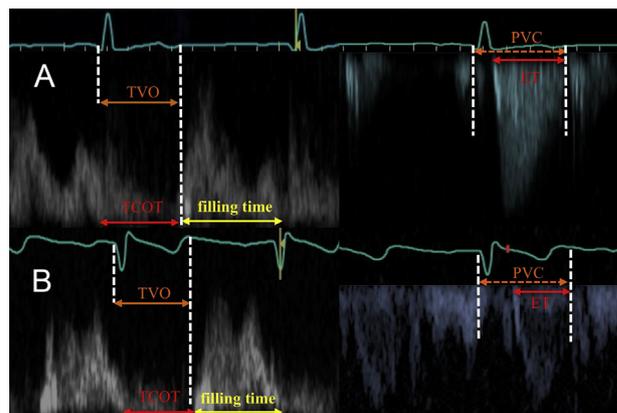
(A) Pulsed-wave Doppler RV inflow and outflow in a control subject (43 years of age) with the following values: HR = 67 bpm, ET = 331 milliseconds, TCOT = 358 milliseconds, TVO = 439 milliseconds, PVC = 427 milliseconds, and filling time = 535 milliseconds. IVRT, MPI, and percentage filling time measure 12 milliseconds, 0.08, and 60%, respectively. (B) Pulsed-wave Doppler RV inflow and outflow in a patient with EA (38 years of age): HR = 82 bpm, ET = 258 milliseconds, TCOT = 357 milliseconds, TVO = 441 milliseconds, PVC = 365 milliseconds, and filling time = 376 milliseconds. IVRT, MPI, and percentage filling time measures 76 milliseconds, 0.38, and 51%, respectively. EA, Ebstein anomaly; ET, ejection time; HR, heart rate; IVRT, isovolumic relaxation time; MPI, myocardial performance index; PVC, pulmonary valve closure time; RV, right ventricle; TCOT, tricuspid closure-to-opening time; TVO, tricuspid valve opening time.
